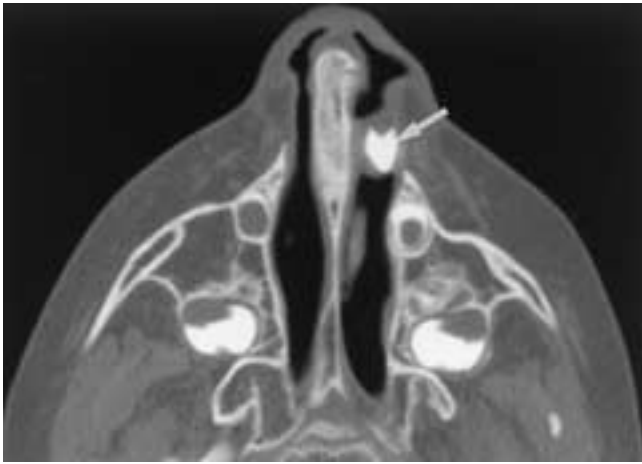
Supernumerary tooth in a 5-year-old boy with chromosomal abnormalities, multiple congenital anomalies, sleep apnea, and left facial pain. Axial CT shows the supernumerary tooth (*arrow*) obstructing the left pyriform aperture.
